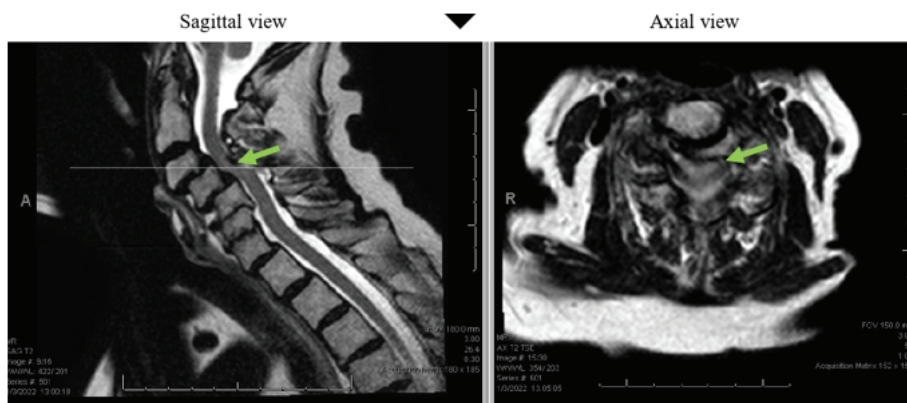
MRI of cord compression at C3-C4 preoperatively.
